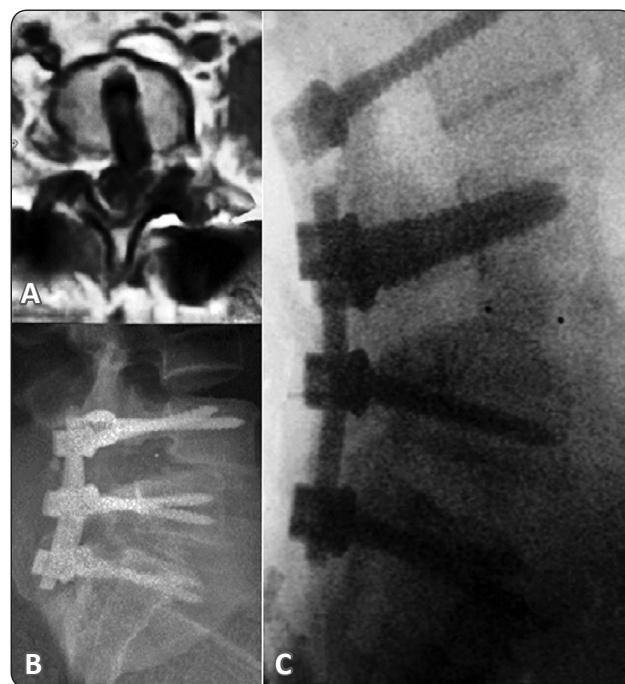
Cage retropulsion in 42 years old female. (A) MRI axial radiographs revealed large retropulsed cage. (B) Lateral X-ray film revealed loosening of the L4 screws and retropulsion of the cage, with sagittal imbalance. (C) Intraoperative L3/S1 lateral X-ray showed construct augmentation with more proximal anchorage point, cage reapplication inside L4/5 space with iliac crest bone graft aiming for bony fusion.
